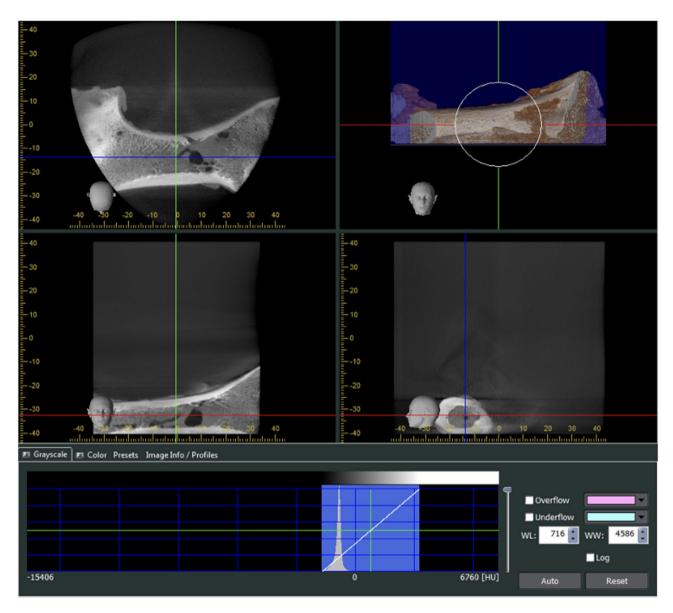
Determination of bone densities with CBCT imaging
